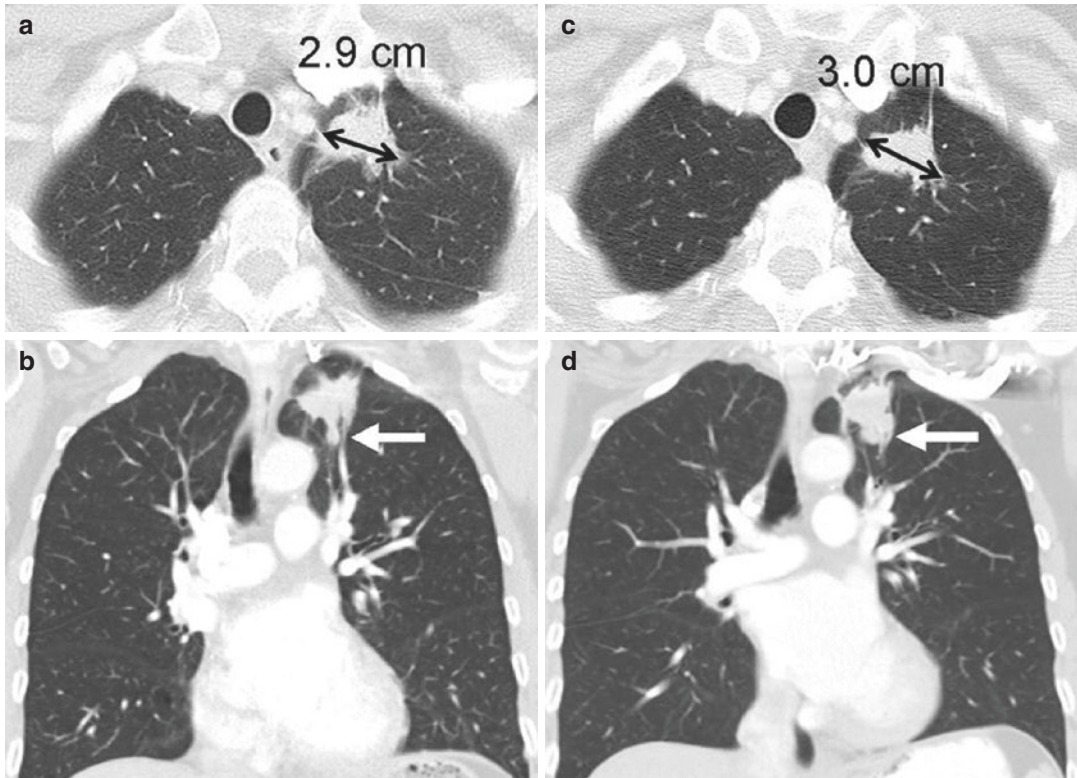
Limitations of response assessment using RECIST in a 58-year-old woman with stage IV adenocarcinoma of the lung. (a, b) Contrast-enhanced axial and coronal CT images of the chest during pemetrexed and cisplatin therapy demonstrate a spiculated mass in the left upper lobe. The measurement of the dominant mass according to RECIST was 2.9 cm, measured in the longest diameter on an axial plane. Note a small nodular component of the mass at its inferior portion on coronal view (arrow, b). (c) At follow-up CT during therapy, the axial
